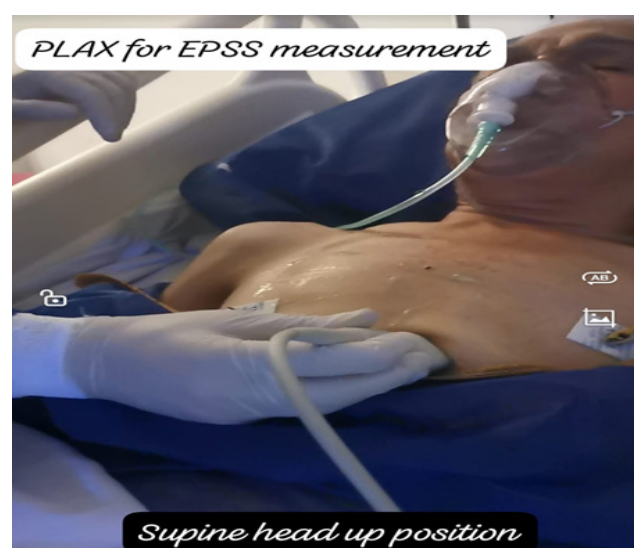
Parasternal long axis Echo measurement of EPSS.
